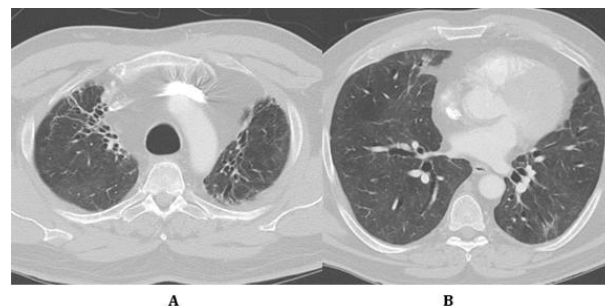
A: HRCT chest of upper lobes showing significant reduction in GGOs and patchy opacities; B: HRCT chest of lower lobes showing reduction in bronchiectasis.
